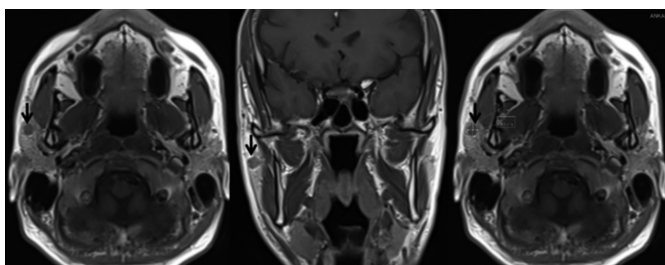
Measurement of the long and short axis diameters of the lymph node (black arrow) in the parotid gland on axial and coronal T1-weighted MRI.
